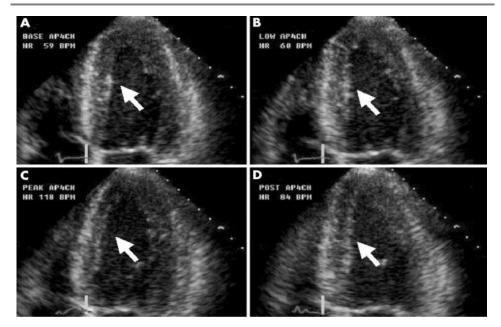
SWMA induced with stress echocardiography. ²⁴
